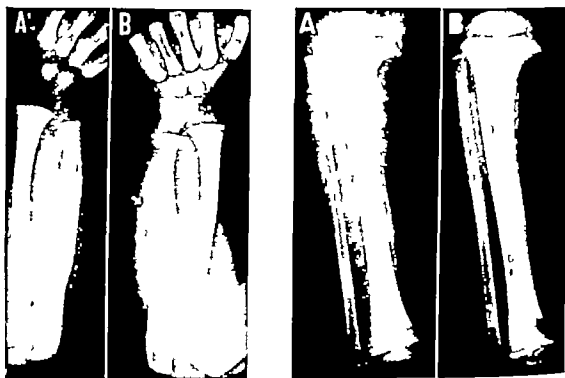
Hypervitaminosis A. (From Dr. John Caffey and reproduced with permis-sion from *Pediatric X-ray Diagnosis*, ed. 2, p. 748, Chicago Yearbook, 1950.) White female, 21 months old. The patient had received 1 teaspoonful of oleum per comorphum daily for 9 months. Anteroposterior views of forearms and leg. Roent-genograms of both ulnas (A and B) were taken 5 weeks after onset and show bilateral symmetrical cortical hyperostosis as a result of vitamin-A poisoning. Tibia (A) 5 weeks after onset shows cortical hyperostosis and spur on the medial aspect of the proximal end of the tibial shaft. (B) 10 weeks after onset and 5 weeks after stopping vitamin A shows increased mineralization and incorporation of the periosteal reaction into the tibial shaft.
